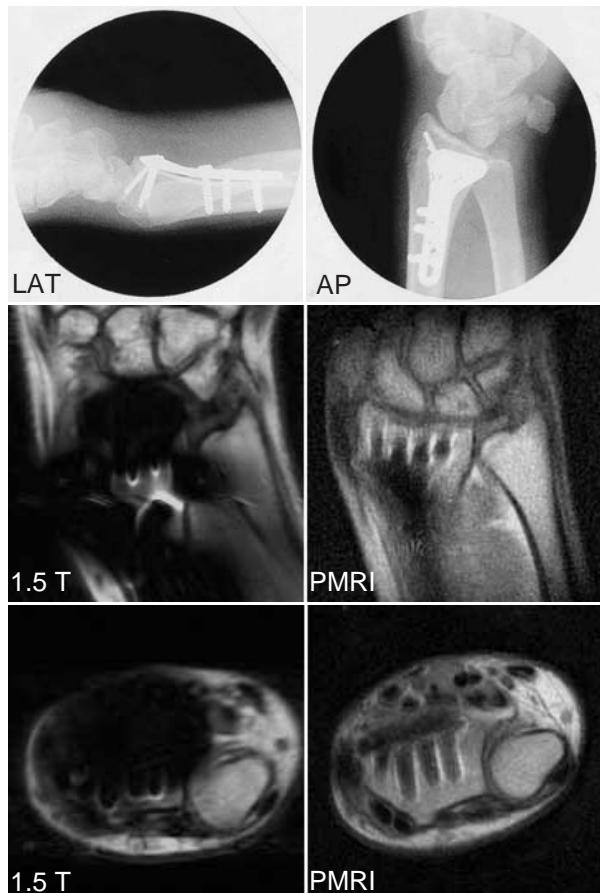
Comparison between 1.5 T and PMRI (54 mT). Lateral and AP radiographs (top) with coronal (middle) and axial (bottom) spin-echo MR images of an *in vivo* human wrist with a metal plate and screws. Pile-up, blowout and distortion artifacts render useless the 1.5 T images (left). The plate and screws in the PMRI images (right) have only minor artifacts, however, making it possible to visualize the alignment of the radio-carpal joint, the distal radio-ulnar joint, and the flexor and extensor tendons near the plate.
